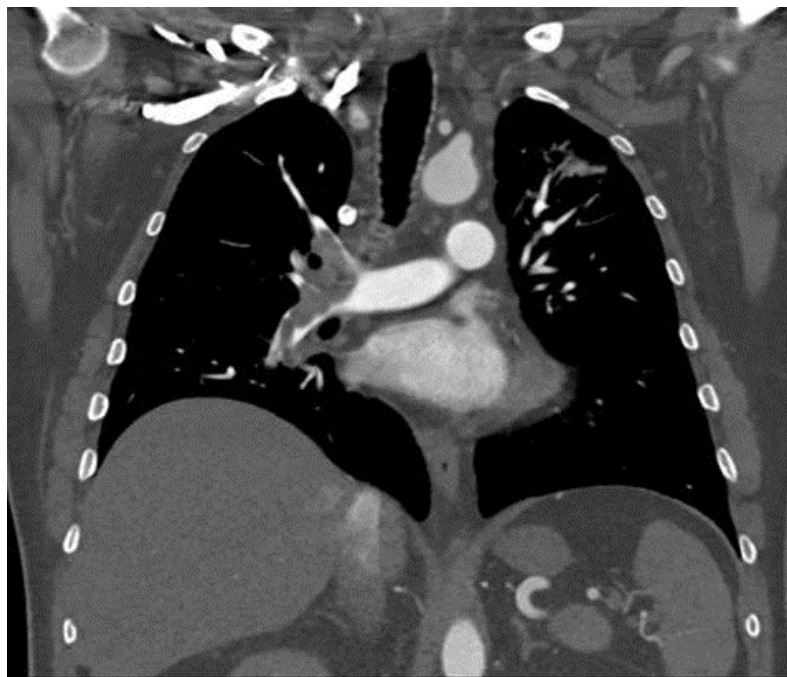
Coronal section of the CT angiogram showing occlusive thrombosis on the right pulmonary artery.
